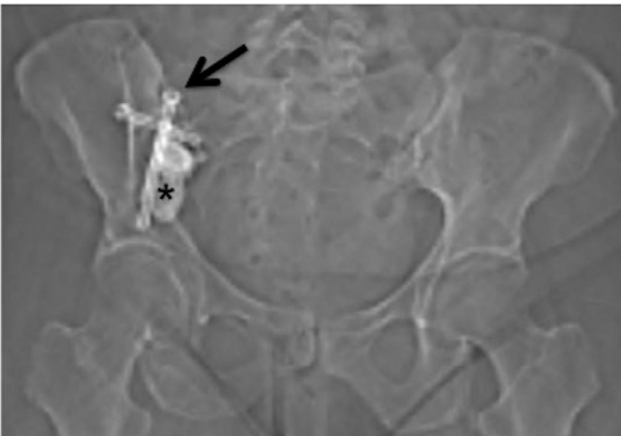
(Patient 1) Scout topogram image from computed tomography within the first month postprocedure, shows a limited over-view of the procedural implants (better depicted than on maximal intensity projection reformats or multiplanar computed tomography) with anterior projections of the iliac and sacral fixation screws (arrows) and cement osteoplasty (*) without complication.
